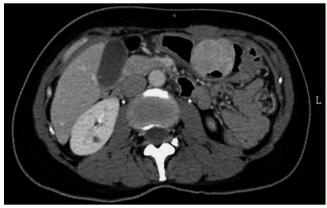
Abdominal computed tomography (CT) scan demonstrating a strongly enhancing mass, approximately 5.5 cm in size, with surface ulceration, arising from the submucosal layer of the anterior wall of the lower gastric body.
